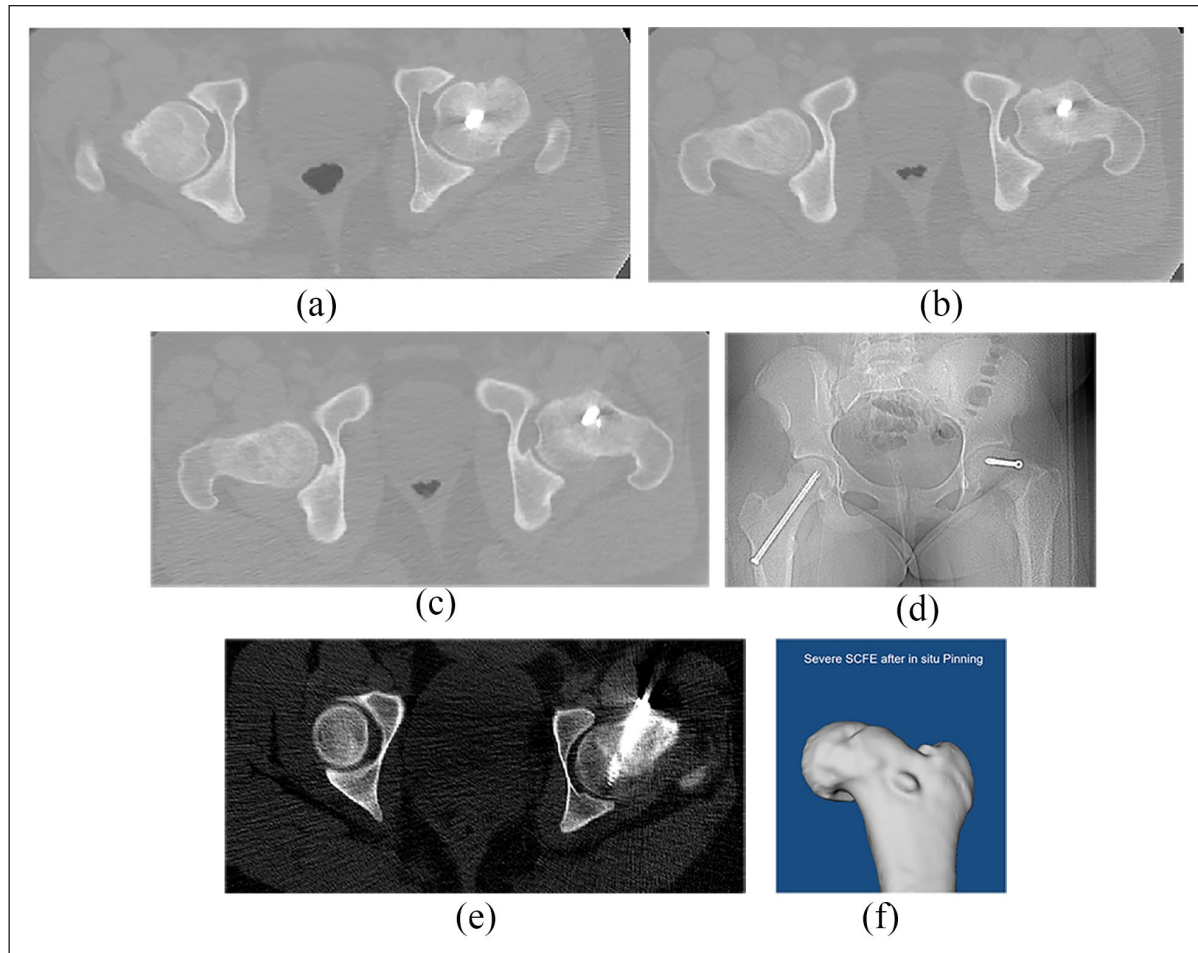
(a–f) Pelvic CT scan of a patient with severe SCFE treated with in situ pinning (a–c). Anteroposterior (AP) pelvis radiograph (d) and corresponding pelvic CT scan (e) of a second patient with severe SCFE treated with in situ pinning. Femoral CT-based 3D model of another patient with severe SCFE after previous in situ pinning (f).
